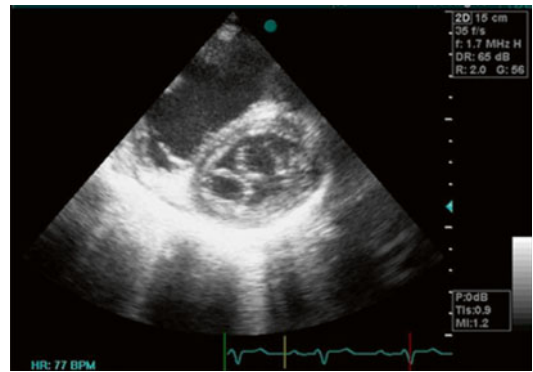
Transthoracic echocardiography in short-axis view showing divided mitral orifice into two components *DOMV* double orifice mitral valve (Video 40.1)
